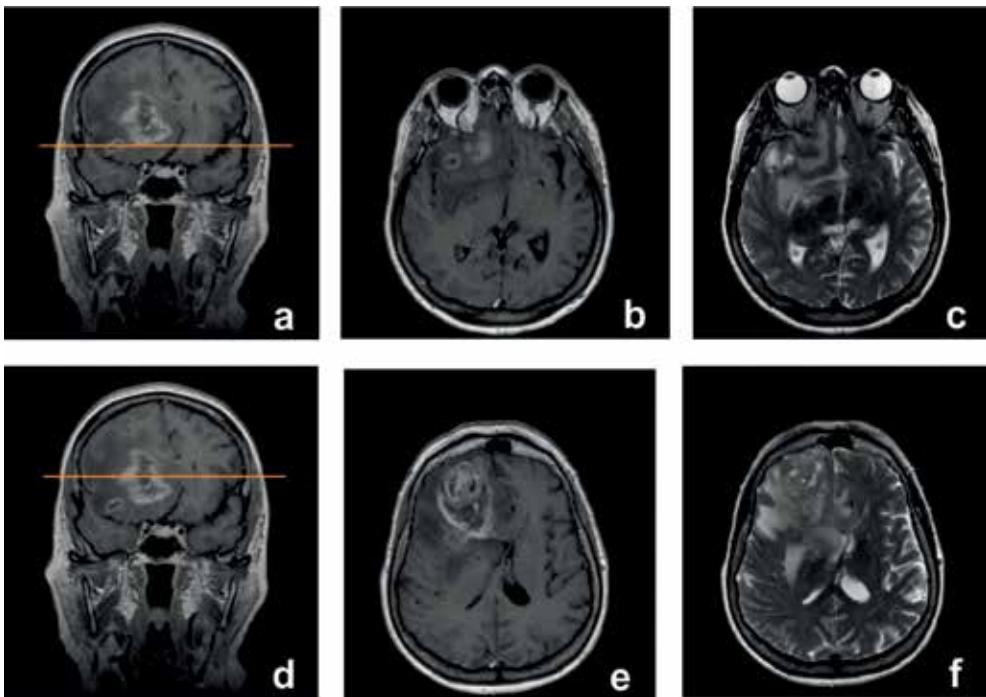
Multifocal glioblastoma – MRI features. There are two separate tumor foci in the right frontal lobe: A smaller one in the basal frontal region and a bigger one in the anterior frontal region. The presence of connecting signal alteration in T2-weighted images defines multifocal lesions. (a) Coronal T1-weighted image with contrast, with section line at the level of smaller tumor; (b) axial T1-weighted image with contrast – Section level is indicated in (a); (c) axial T2-weighted image – Section level is indicated in (a); (d) coronal T1-weighted image with contrast, with section line at the level of bigger tumor; (e) axial T1-weighted image with contrast – Section level is indicated in (d); (f) axial T2-weighted image – Section level is indicated in (d).
